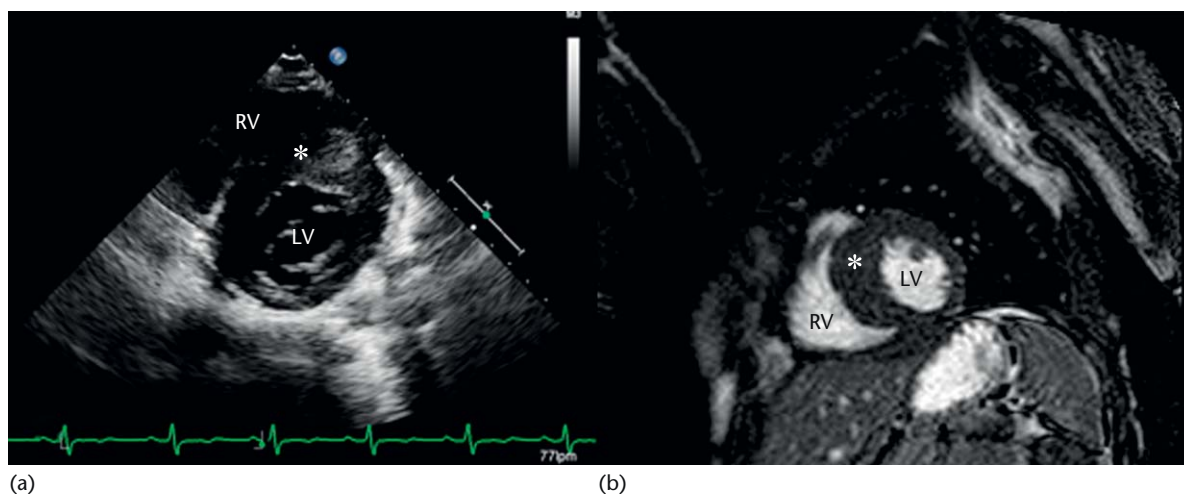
Two-dimensional echocardiogram performed in the parasternal short-axis view (a) and coronal view of magnetic resonance angiography (b) showing left ventricular hypertrophy involving the intraventricular septum (asterisk). RV: right ventricle, LV: left ventricle.
